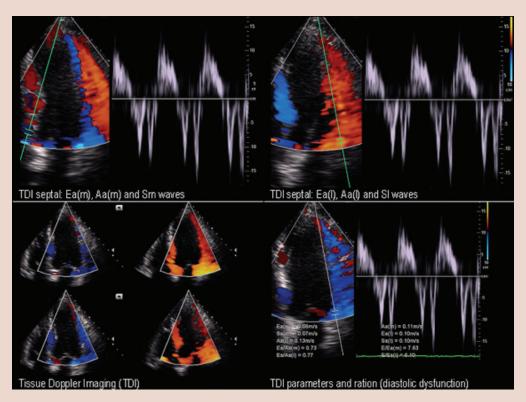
Echocardiography and Doppler study showing parameters of TDI in diastolic dysfunction.
